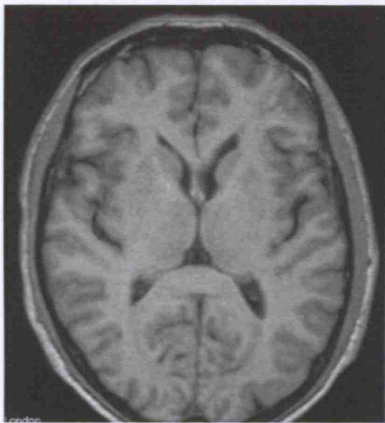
Example of contrast in a T1-weighted image, note high contrast between grey and white matter
